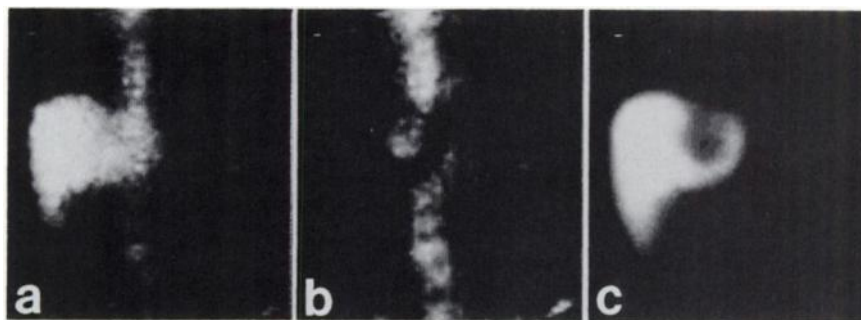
(a) Indium-111 leukocytes. (b) Subtraction of liver area. (c) Tc-99m(Sn)colloid. (d) Repeated scan. Case 4. After endoscopic papillotomy, a 70-yr-old woman presented with upper-abdominal tenderness. Ultrasound was inconclusive. Computerized tomography revealed enlarged pancreas with multiple cysts. Subtraction scintigraphy revealed increased activity over whole pancreatic area, with maximum activity in cephalic part. After conservative treatment and clinical improvement, repeat scan showed less activity in pancreatic area and obvious colonic uptake. Impression: spontaneous drainage into GI tract.
